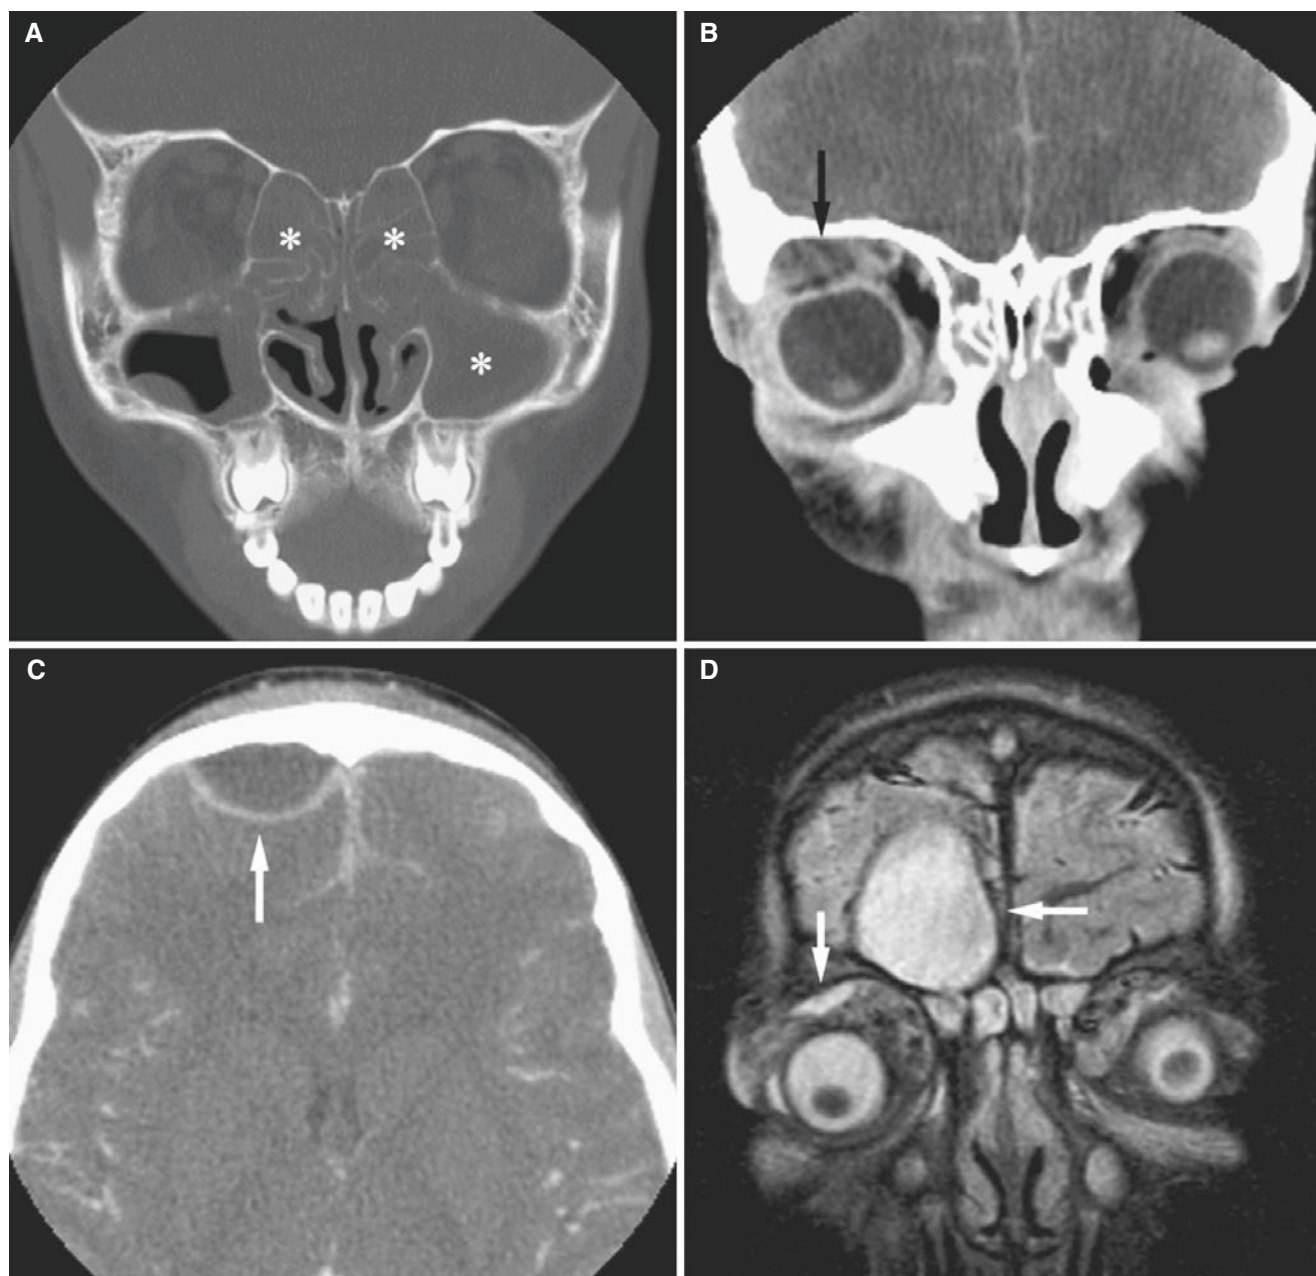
Intracranial empyema from sinusitis; 9-year-old female presenting to emergency department with headache, fever, right eye edema, and ecchymosis. (A) Coronal CT image shows complete opacification of both ethmoid and left maxillary sinuses (*asterisk*) and mucosal thickening of the right maxillary sinus; also sphenoid and frontal sinuses showed opacification (not shown). (B) Coronal post-contrast CT image, soft-tissue window, shows hypodense central area with enhancing periphery consistent with abscess in the superior right orbit with displaced globe (*arrow*). (C) Axial post-contrast CT image, soft-tissue window, shows abscess in the right frontal region (*arrow*). (D) Coronal FLAIR MRI shows high signal in orbit superiorly and anterior
